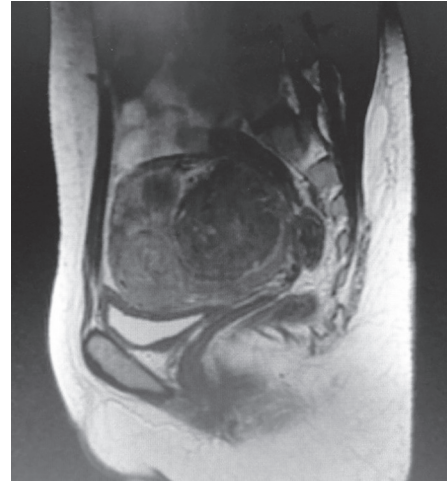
MRI image—pelvis
